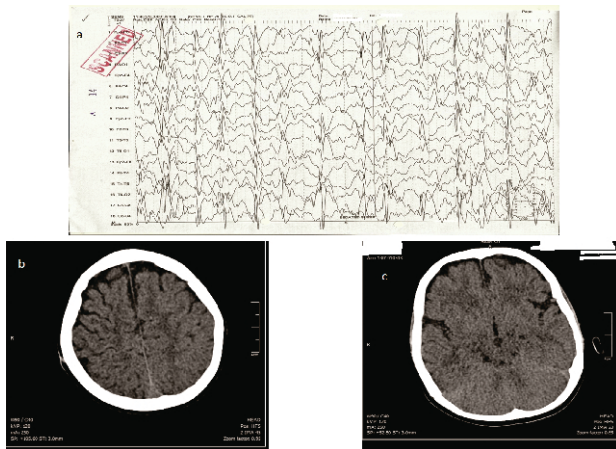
Electroencephalogram and CT scan of affected girl a: EEG shows generalized spike b and c: CT scan of brain showed bilateral atrophic changes
